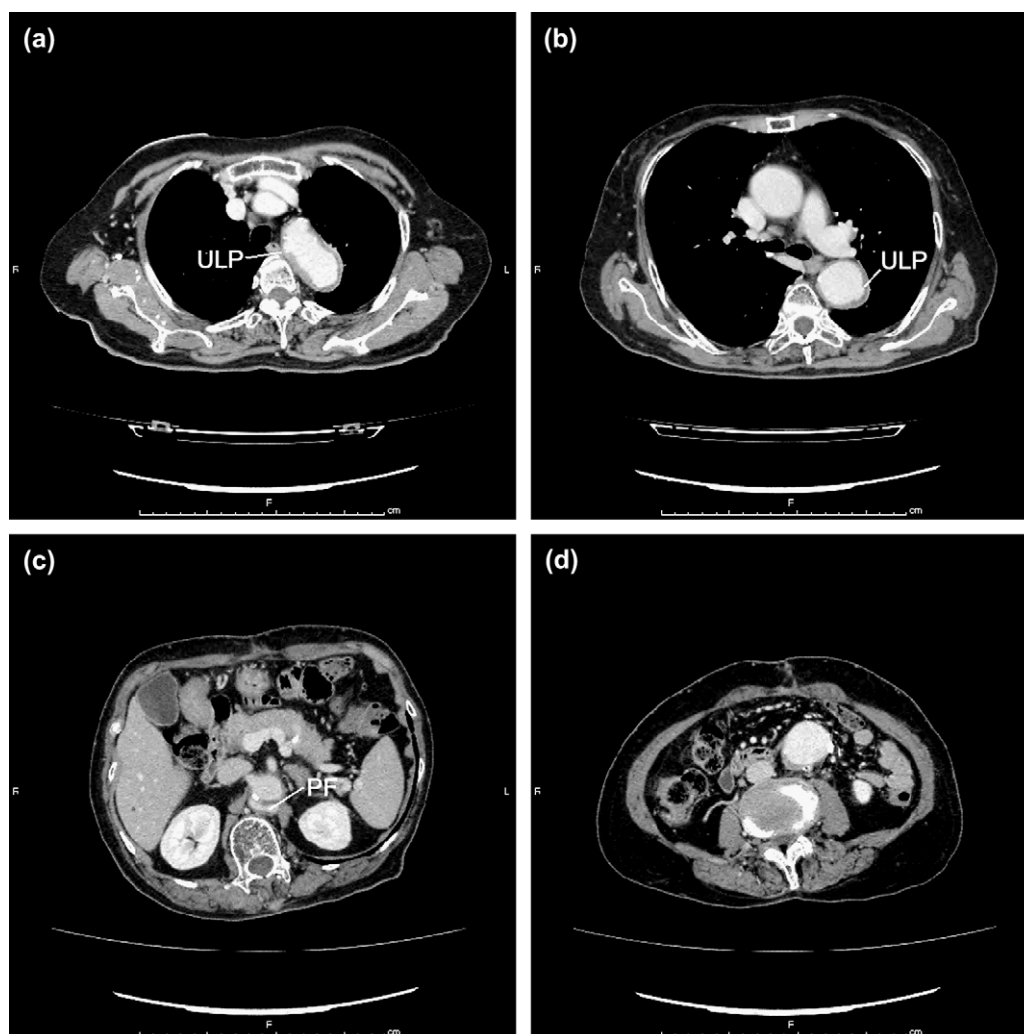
(a) Computed tomograph 4 months after operation at the distal arch level, now showing a small ULP. (b) Computed tomograph 4 months after operation at the carina level also showing a ULP. (c) Computed tomography 4 months after operation at the right renal artery level. Compared to Fig. 2-c, prior to surgery, this shows a smaller but still patent false lumen (PF). (d) Computed tomography 4 months after operation around the previous suture line showing neither anastomotic aneurysm nor retroperitoneal hematoma.
